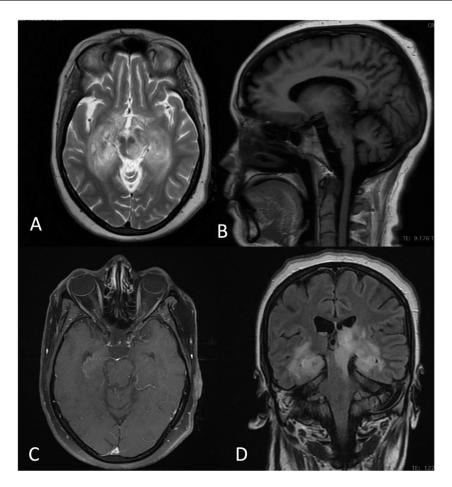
A 35-year-old female, with a history of Behçet's disease and a right body weakness, presented an acute loss of consciousness. Cerebral MRI showing signal abnormality. (A) T2-weighted image in axial view showing hypersignal of the corpus collosum and the midbrain. (B) T1-weighted image in sagittal view showing hyposignal of the thalami and the meso-diencephalic junction. (C) T1-weighted image with contrast in axial view showing a leptomeningeal enhancement at the right temporal region. (D) FLAIR sequence in coronal view showing bilateral and asymmetric hypersignal of the left thalamus, the left internal capsule, hippocampi, midbrain and meso-diencephalic junction surrounded by a vasogenic edema and a mild rightward midline shift: The cascade sign [9].
